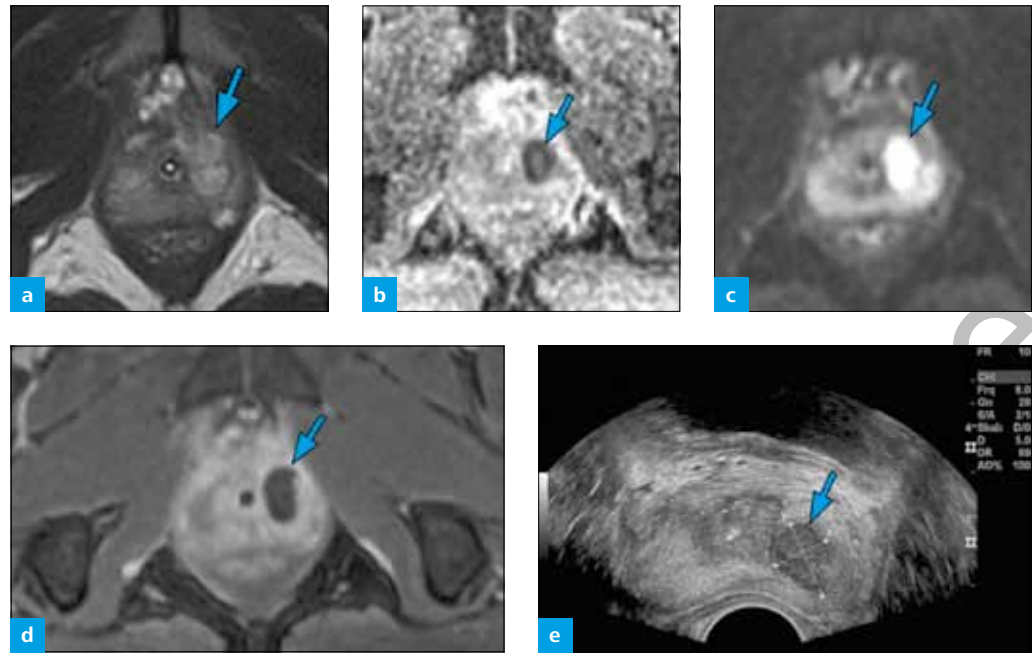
T2-w image in (a) axial plane with (b) ADC map and (c) DWI, (d) T1-w image with fat saturation after contrast; all without an endorectal coil and (e) B mode TRUS: abscess of the prostate shows a discrete increase of signal intensity in T2-w MRI (arrow in a), a marked decrease on ADC (arrow in b) and a circumscribed restriction of diffusion (arrow in c), rim enhancement within the capsule of the abscess (arrow in d) and a hypoechoic, inhomogeneous structure in B mode TRUS.
